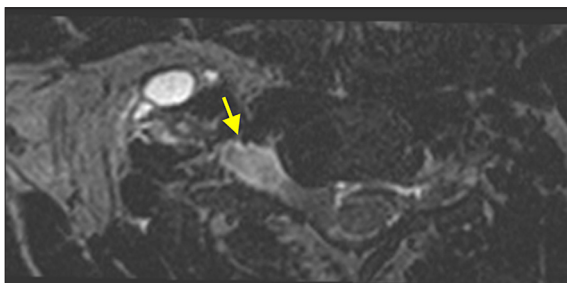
Brachial plexus MRI (T2 sequence, axial plane) revealing meningocele at C6-C7 level (yellow arrow), less evident due to the hematic component.
